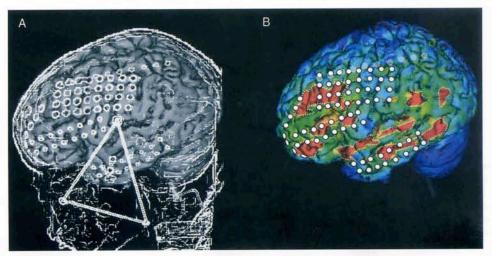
X-ray-based identification of subdural grid electrodes for PET co-registration on the three-dimensional brain surface, reconstructed from volumetric MRI. A. The X-ray and MRI image datasets are co-registered using fiducial markers (two on the left and one on the right side), which form a triangle in the image space. B. Locations of the grid electrodes derived from the co-registered X-ray, superimposed to the brain surface, showing the objectively defined PET abnormalities in the left frontal and temporal cortex. A 1 × 10 electrode grid is located in the medial frontal–temporal area and cannot be directly visualized on the lateral surface.
